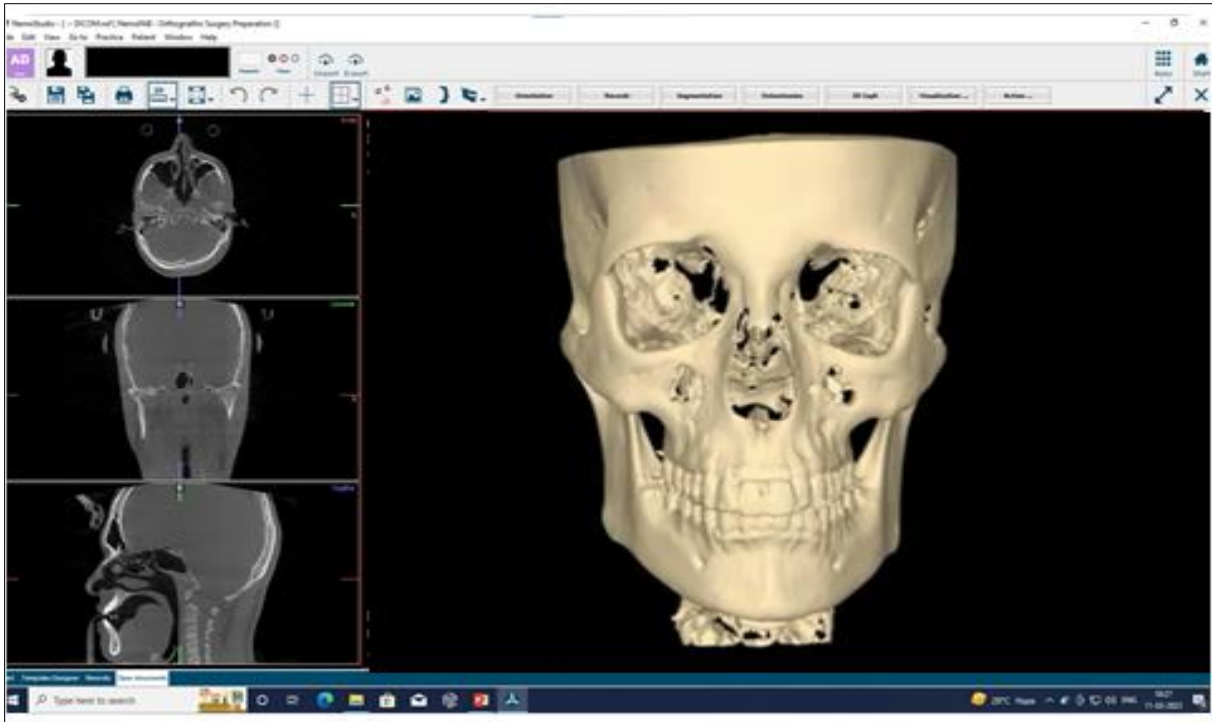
CBCT reconstructed 3D model
